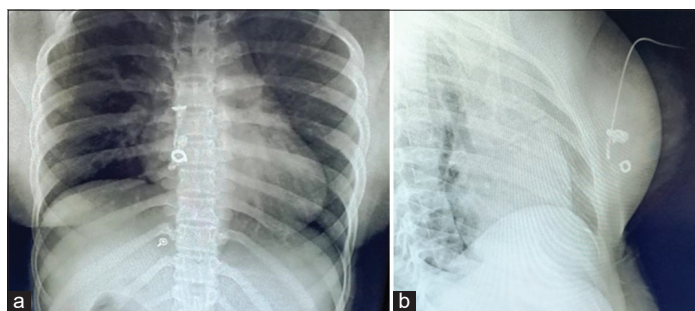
X-ray sinogram (a) anterior view; (b) lateral view
